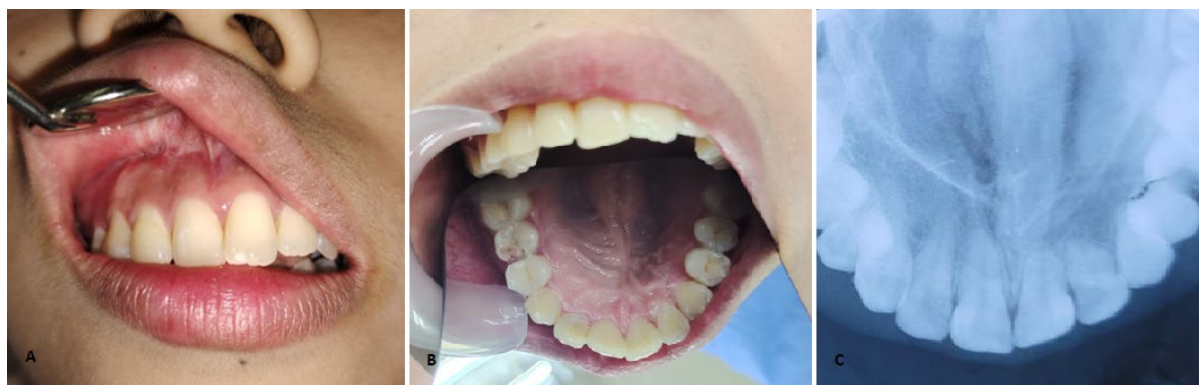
Progress of patient one-year post enucleation. (A) Slight scarring of upper buccal sulcus with no palpable bulge (B) Well recontoured palate, and (C) Upper occlusal radiograph showing new bone formation in the previous enucleated cyst cavity and resorption of root tips teeth 11 to 14 persist.
